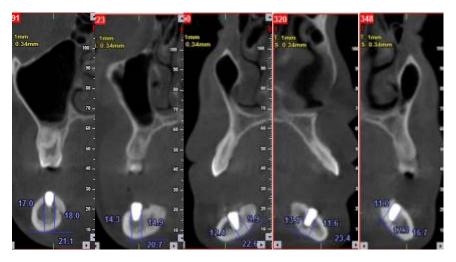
cone beam computed tomography immediate after implant placement
